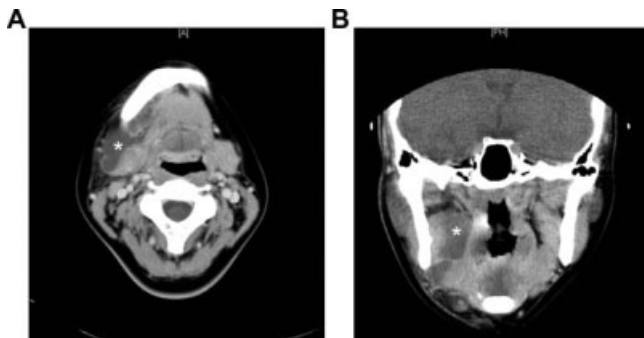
(A) Axial view computed tomography CT scan of patient 14, showing low-intensity mass in anterior neck region. (B) Coronal view CT showing a submandibular region cystic mass (*), which had no definite relationship with SLG and was difficult to differentiate from lymphangioma.
